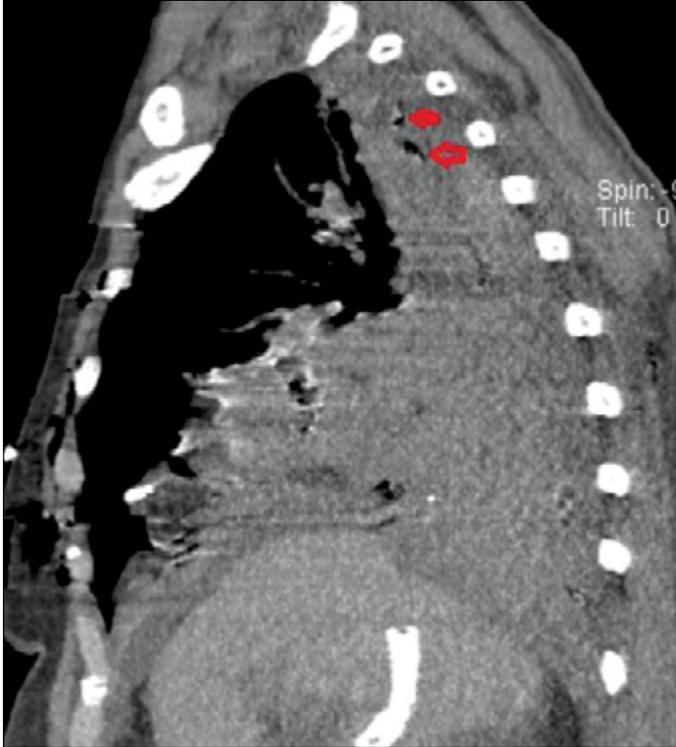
Chest computed tomography showing pneumomediastinum (arrow)
